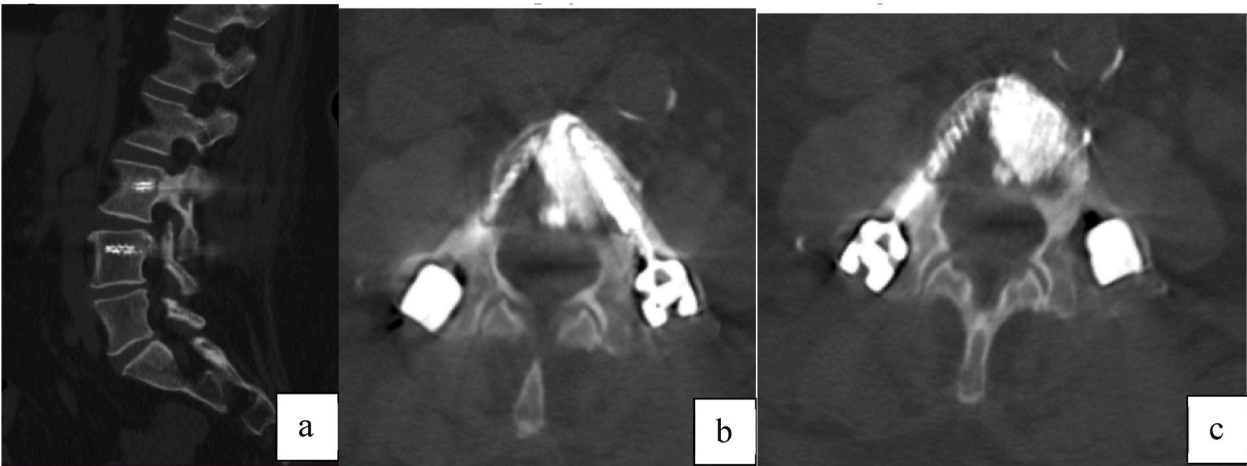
a, b, c: CT scan at 6 months from surgery. Callus formation on the pedicles is evident.
